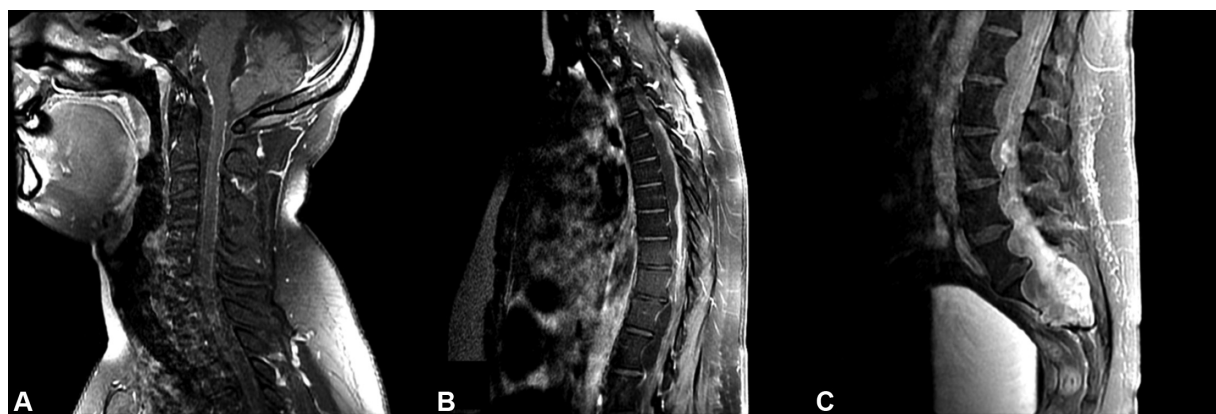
T1-weighted magnetic resonance imaging with gadolinium. Diffuse leptomeningeal enhancement to the gadolinium injection in the (A) basal cisterns, 4th ventricle, and cervical spinal cord, (B) thoracic spinal cord, and (C) lumbar spinal cord, and cauda equina.
